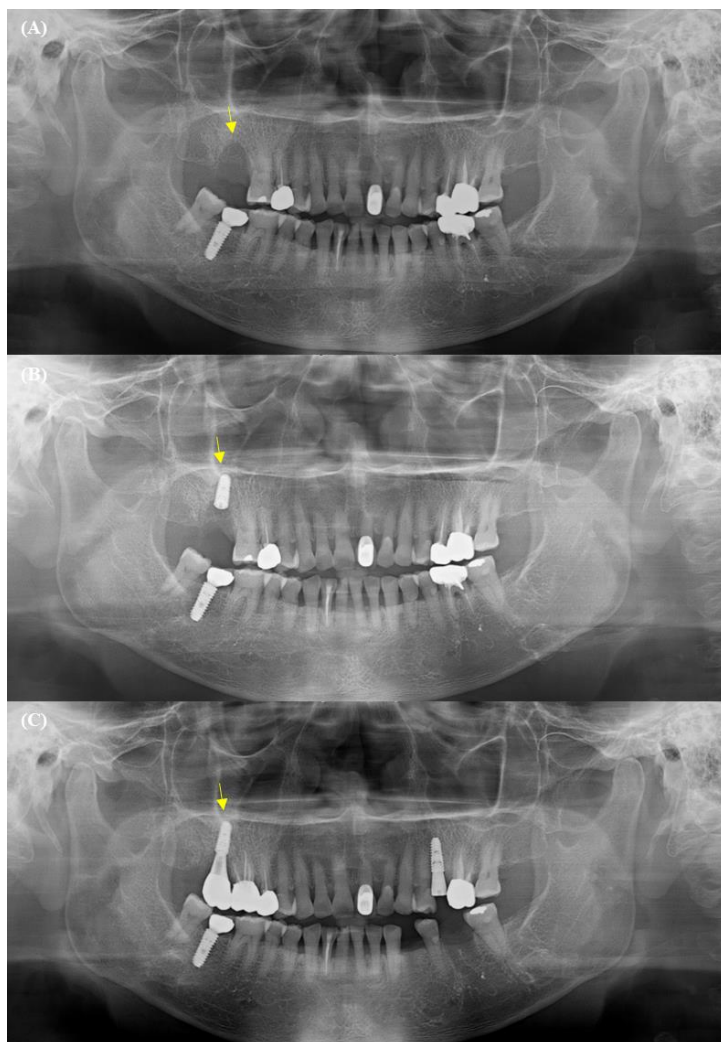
MRONJ case 3; (A) Panoramic radiograph taken at the initial visit, showing an MRONJ lesion in the right posterior maxillary region, (B) Panoramic radiograph following first-stage implant surgery in the right posterior maxillary region, (C) Panoramic follow-up radiograph of the right posterior maxillary region. Yellow arrows indicate areas of MRONJ lesions.
